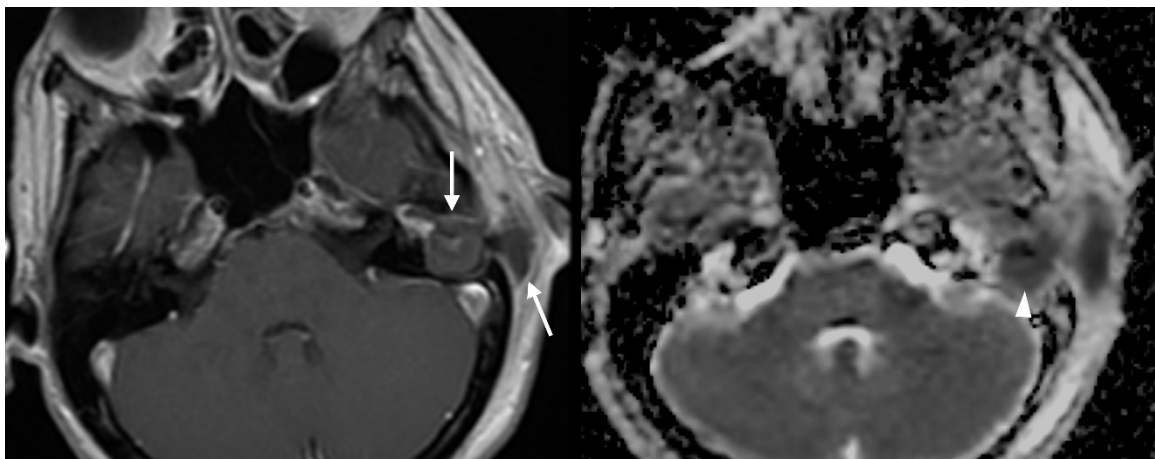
29-year-old female with complicated coalescent mastoiditis. Post-contrast T1-weighted image (A) shows a hypo-enhancing region from the left mastoid to the adjacent subcutaneous area with an enhancing rim (arrows), consistent with coalescent mastoiditis
